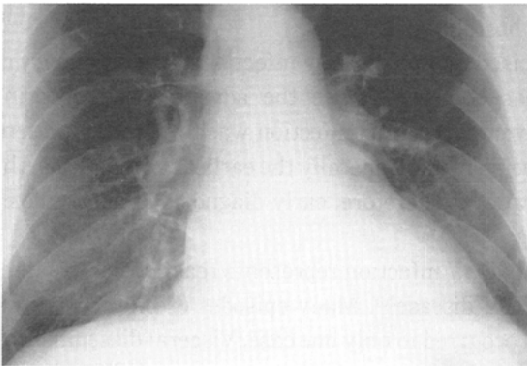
(Case 6) *H flu* infection. PA chest radiograph 10.5 months after cardiac transplantation shows subtle interstitial opacities in both bases.
